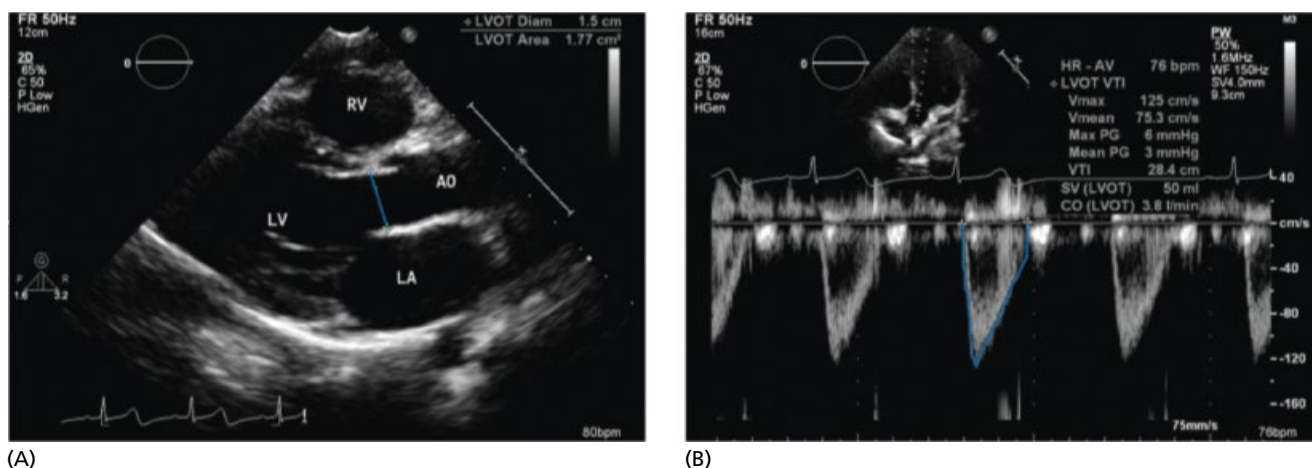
The left ventricular outflow tract (LVOT) diameter is measured in the parasternal long axis view (A) and the use of pulsed Doppler for the measurement of the velocity-time integral (VTi) is obtained in the five-chamber apical view (B). Cardiac output (CO) = SV × HR and SV = VTi × LVOT cross-sectional area. The LVOT cross-sectional area = $\pi/4 \times (\text{diameter}/2)^2$. *Source:* Reproduced from Gaspar and Morhy [334]. Gaspar, <https://www.hindawi.com/journals/bmri/2015/596451/abs/>. Licensed under CC BY 3.0.
